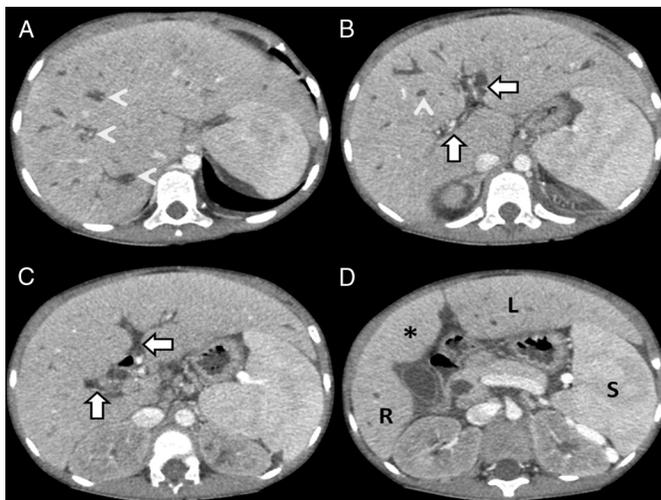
(A) Axial contrast-enhanced computed tomography depicting skip areas of bilobar biliary dilatation with central dot sign (arrows). (B and C) Note absent portal venous branches at the hepatic hilum (arrows). (D) The liver shows volume redistribution in the form of relative right lobe atrophy (R) and compensatory left lobe enlargement (L) with preserved segment IV volume (asterisk). Note the attendant splenic enlargement (S).
